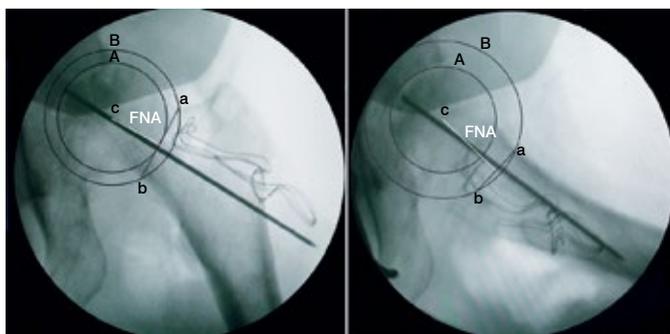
Radiographic assessment of guide pin position in anteroposterior (left side) and lateral (right side) radiographs of the hip; the center of the femoral head (C) is located within circle A. Another circle arc (B) was drawn using the center of the femoral head (C) as the center. Points a and b, where circle B intersects the deepest concave point of the femoral neck, are connected and defined as the transcervical line (ab line). The line drawn perpendicular to the transcervical line through the center of the femoral head (C) is represented as the femoral neck axis (FNA).
